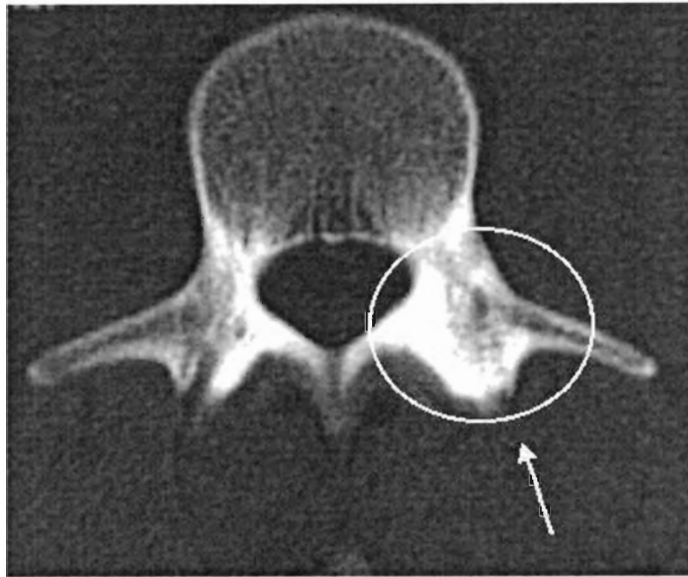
This 21-year-old right arm bowler (subject 7) was diagnosed with an isotope bone scan as having "increased uptake in the postero-lateral 3rd lumbar vertebra, compatible with a stress fracture". This CT scan taken 2 years after the original diagnosis and showed a thickened, healed stress fracture of the left pars interarticularis and a thickened left pedicle.
